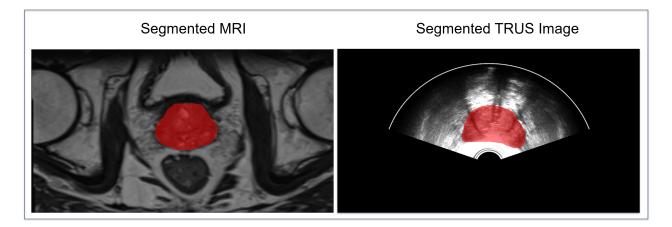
The prostate gland on a MRI (left) and a TRUS image (right) is specified by a radiation oncologist. It demonstrates the change in shape of the patient's prostate while it's under the pressure of the TRUS probe.
